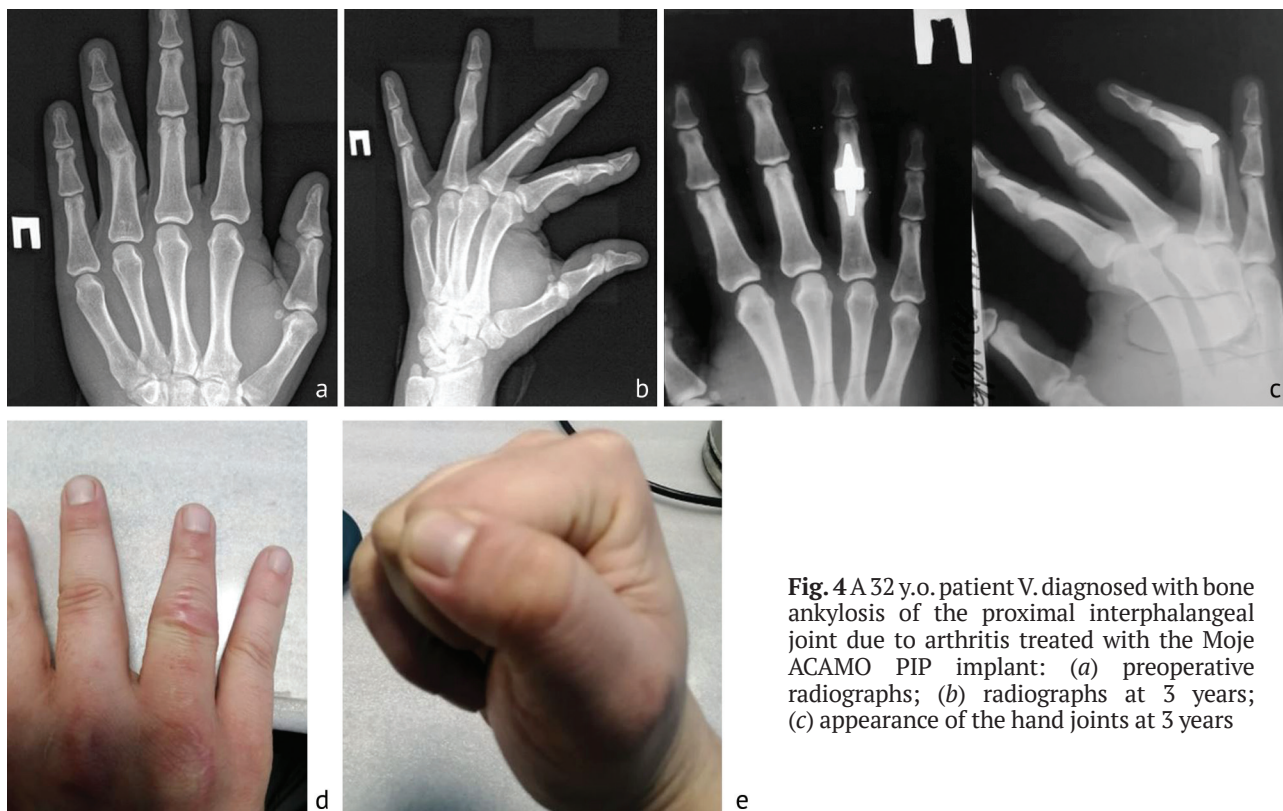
A 32 y.o. patient V. diagnosed with bone ankylosis of the proximal interphalangeal joint due to arthritis treated with the Moje ACAMO PIP implant: (a) preoperative radiographs; (b) radiographs at 3 years; (c) appearance of the hand joints at 3 years
